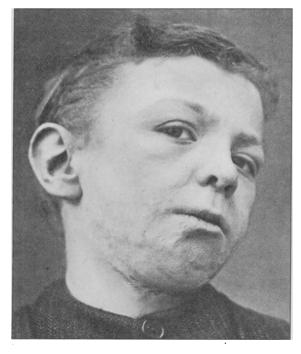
Showing effect of treatment by X-rays.
